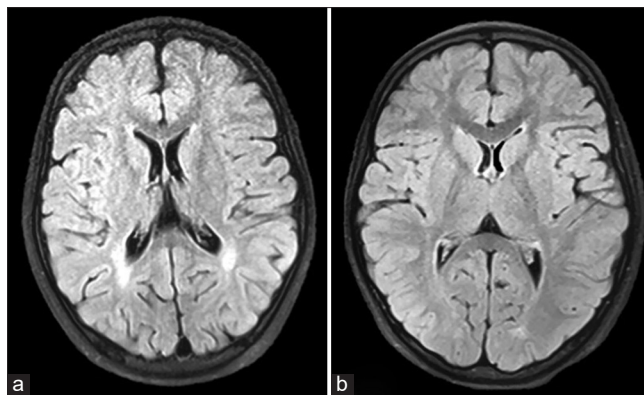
Axial T2-weighted fluid-attenuated inversion recovery magnetic resonance imaging of the brain showing bilateral periventricular white matter hyperintensities (a). Follow-up imaging after 1 year showing complete resolution of the hyperintensities (b)
